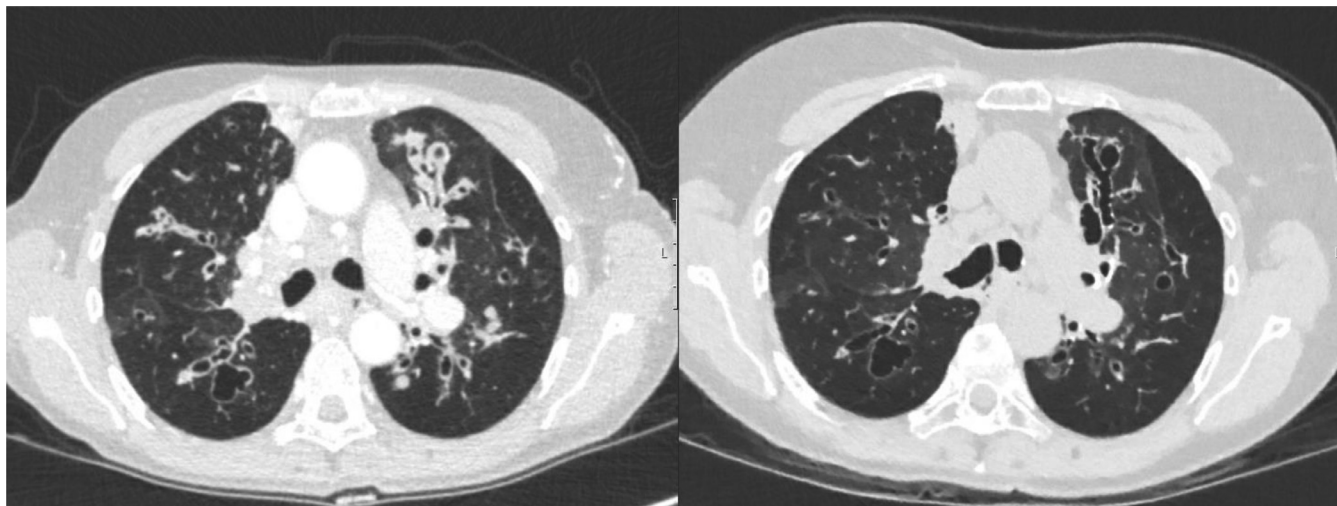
CT scan images of our patient 1 month before start (left) and 3 months after start of treatment (right).
